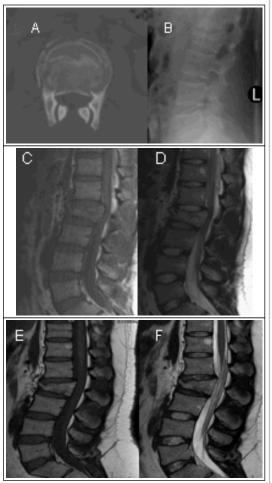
A 19-year-old man fell from a height of 20 feet landing on his feet. On the day of injury, he complains of back pain without deficit. Lateral plain film showed a burst fracture of L2. CT scan (a, b), and sagittal T-1 and T-2 weighted MRI (c, d) show the retropulsion of bone with a residual canal of 75% and minimal kyphosis. Though the posterior longitudinal ligament is stretched, the inter- and supra-spinous ligaments and ligamentum flavum are preserved. The patient was treated non-operatively and hospitalized for 11 days. He did well and was followed annually for 3 years. He returned 8 years later with complaints of 6 months of back and leg pain. Xrays showed an angulation of 15°. The T-1 and T-2 MRI (e, f) shows remodeling of the spine without canal compromise, but persistence of kyphosis. Patient is being treated conservatively with anti-inflammatories.
